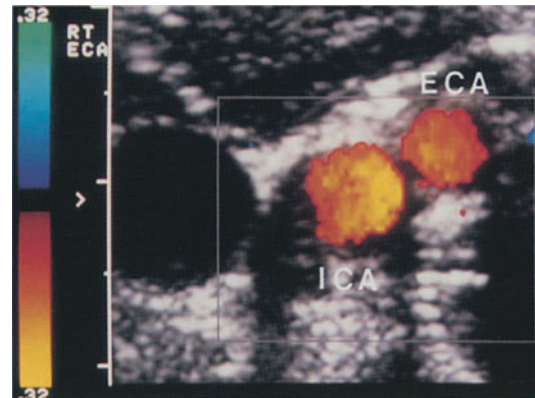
(right) Transverse sonogram above the bifurcation: ECA runs anteromedial to ICA (in 95% of cases)
